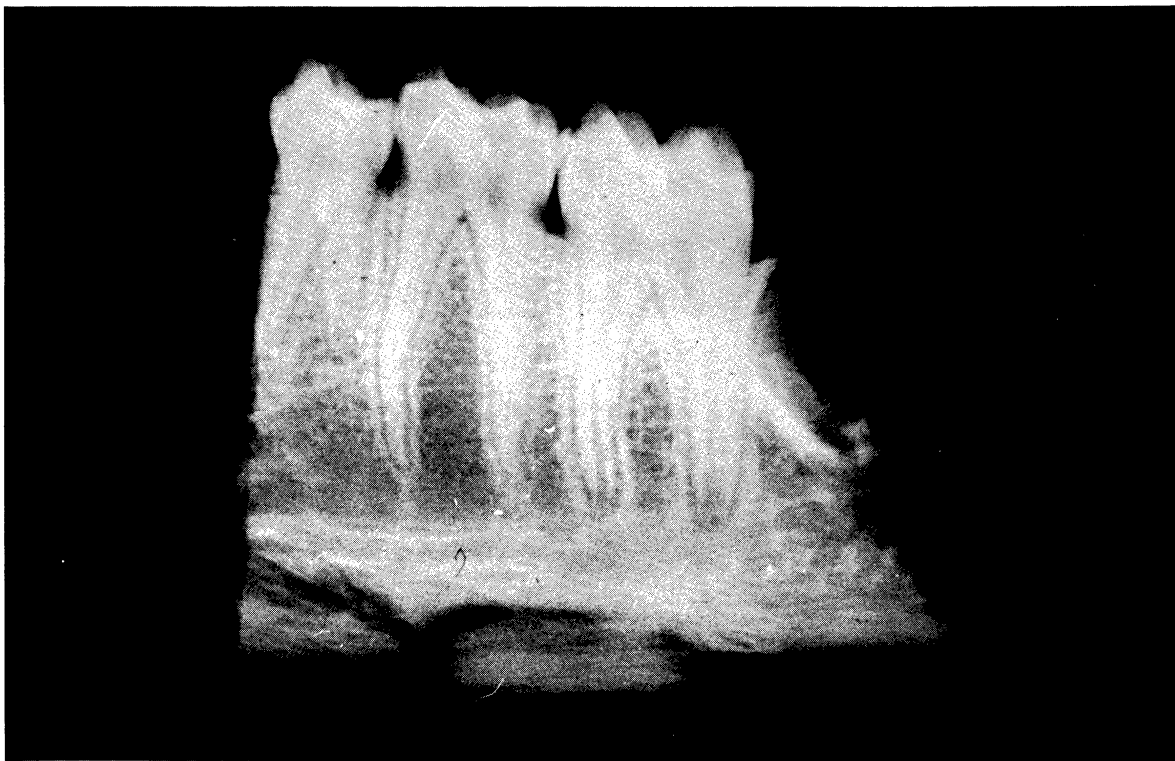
Radiograph taken six weeks after stabilization of mandibular bone graft with adhesive. Questionable bony bridging can be noted.
